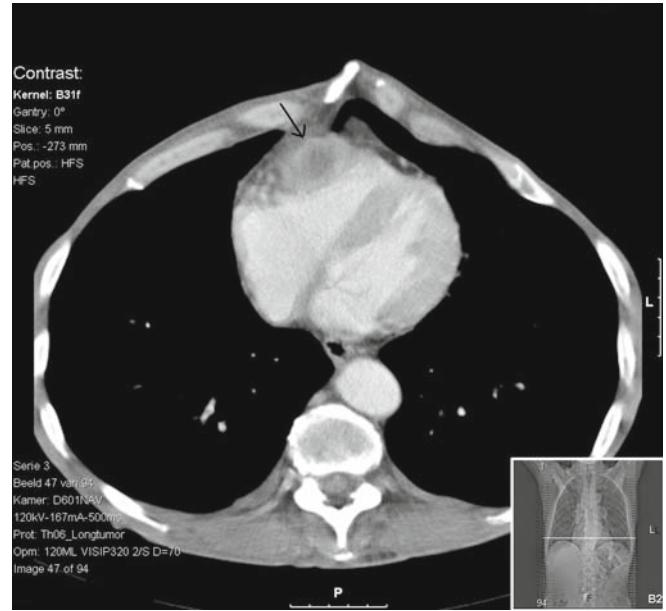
Chest CT scan: performed to evaluate the patient's complaint of atypical chest pain, demonstrating a cardiac mass of 3 × 2.5 cm (arrow)
